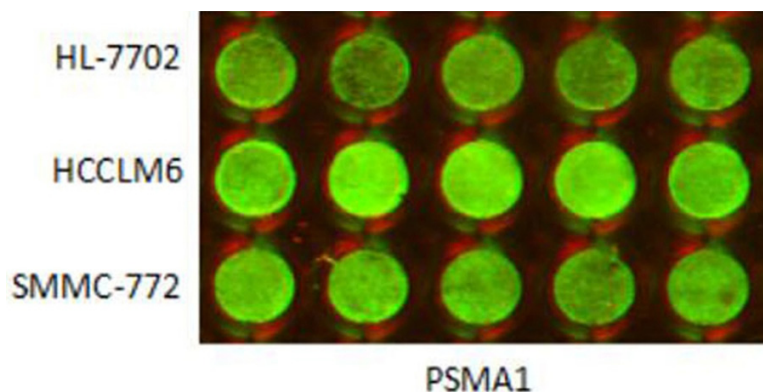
The in-cell western figures of PSMA1.
